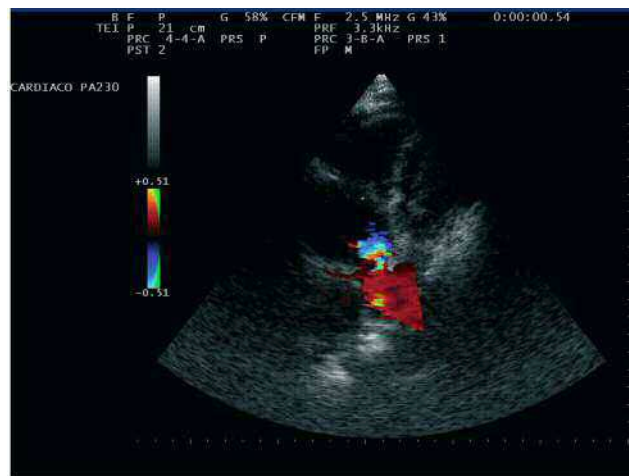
Transthoracic Doppler echocardiography. Parasternal view of pulmonary artery with sclerosis, high transvalvular velocity, and mild regurgitation.
